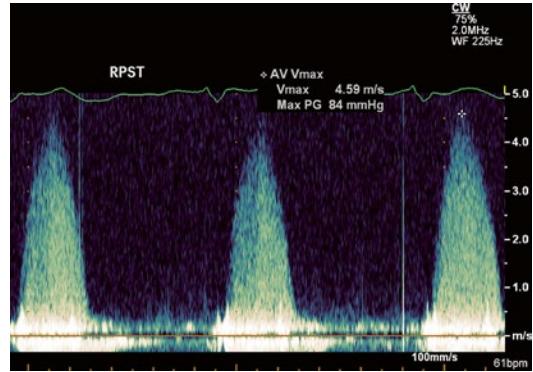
Dedicated Doppler transducer recording from the right parasternal border (RPST) demonstrating peak velocity of 4.59 m/s giving a peak gradient of 84 mmHg. The recording from the apex in this same patient showed peak velocity of the aortic jet of 4.0 m/s and an estimated peak gradient of 64 mmHg, and would therefore have significantly underestimated the severity of aortic stenosis in this individual
